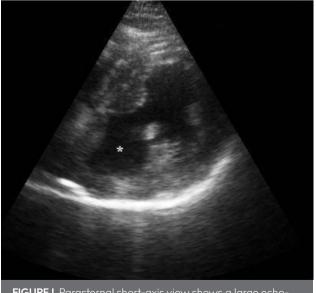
Parasternal short-axis view shows a large echofree space behind the inferior wall that communicates with the left ventricle through a narrow neck
